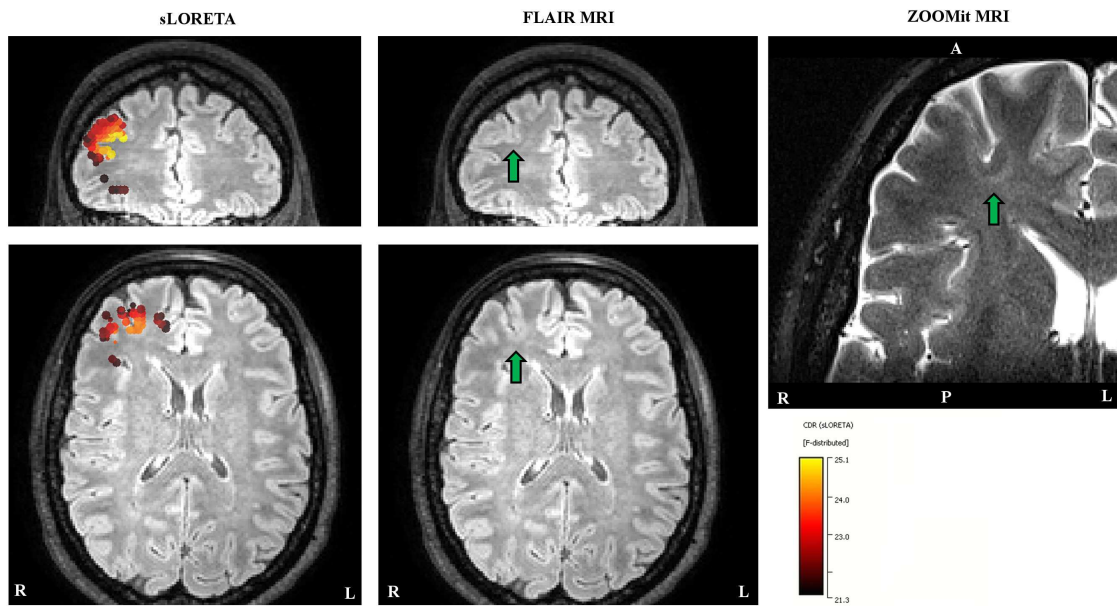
Source localizations at -7 ms. In the left column the sLORETA results projected to the FLAIR MRI are shown (only results obtained with a threshold of 85 % for the maximum F-value are shown). In the middle column, the FLAIR image without the localizations is shown. The right column shows the results of ZOOMit MRI. The green arrows indicate the FCD and the white letters on MRIs show the orientation (L: Left, R: Right, A: Anterior, P: Posterior).
